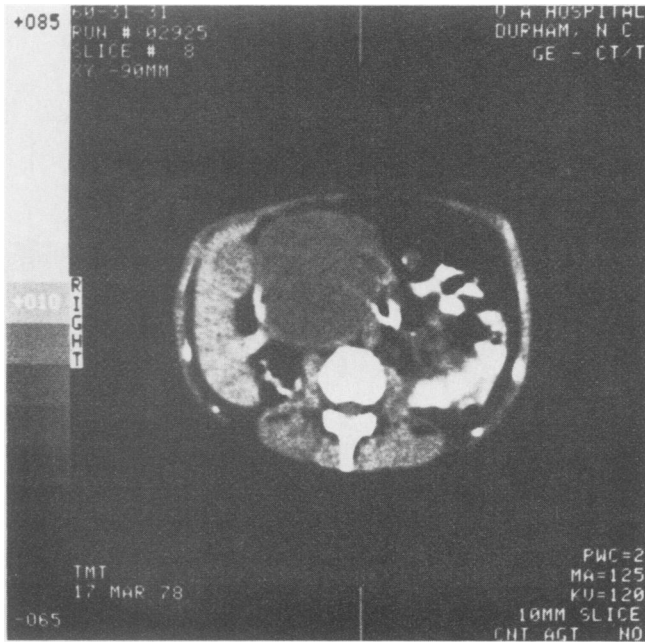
CT scan of pancreatic pseudocyst in transplant recipient.
